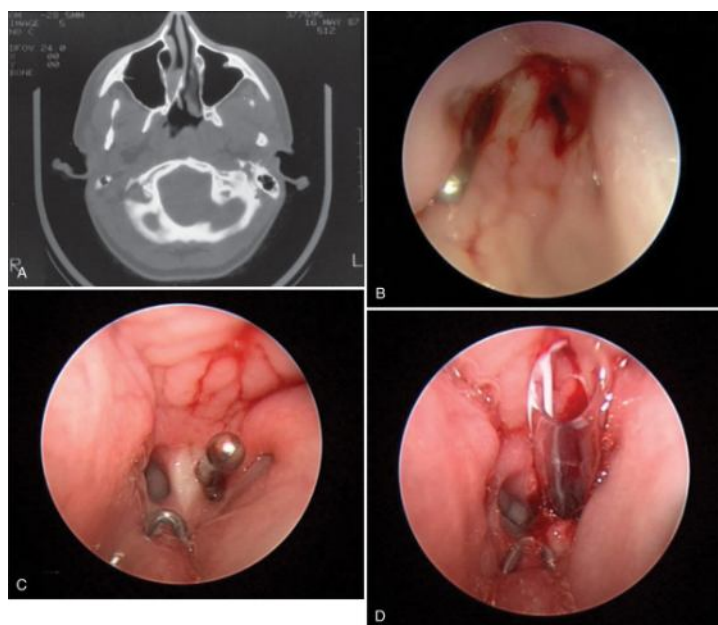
A, Computed tomography scan demonstrating bony choanal atresia of the right side. B, Ninety-degree telescopic view of unilateral choanal atresia. C, Puncturing choanal atresia. D, Stenting of the posterior choana.
